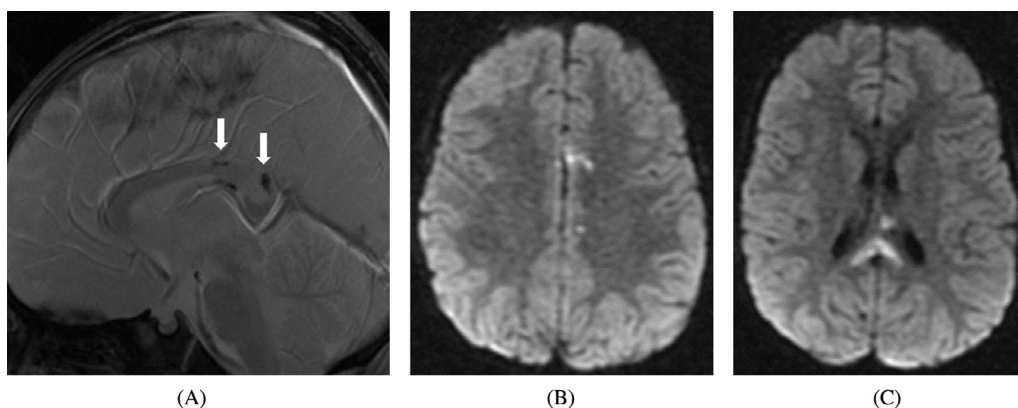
Diffuse axonal injury. (A) Sagittal T2* sequence from a brain MRI examination of a 2 years old subjected to AHT, who presented with altered mental status, demonstrates edema and hemorrhagic foci in the posterior corpus callosum consistent with DAI. (B and C) on DWI there are multiple foci of restricted diffusion in the corpus callosum and in the left cerebral hemisphere.
